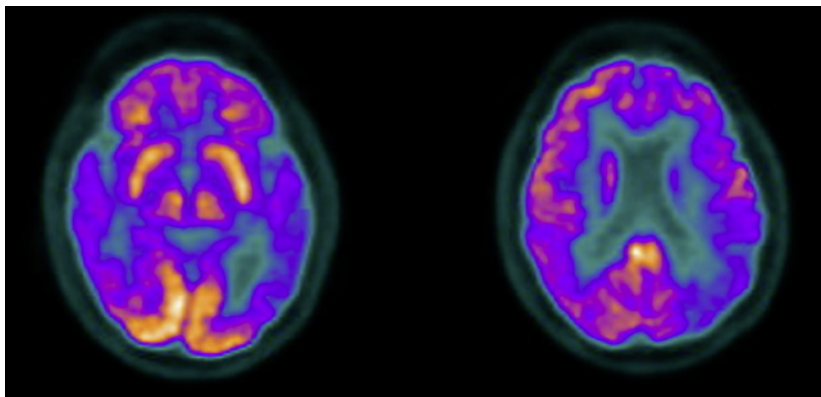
Brain FDG-PET of patient 2, revealing moderate temporal and parietal hypometabolism.
